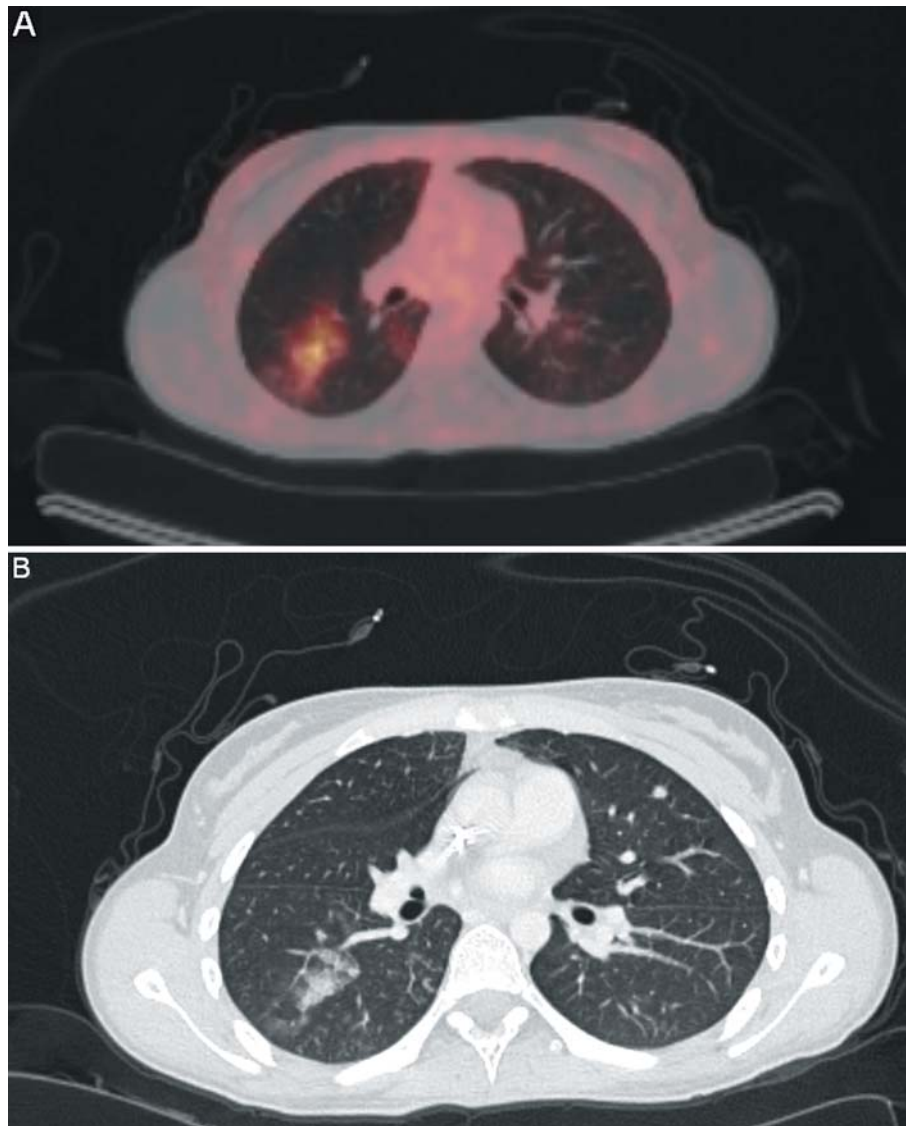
Fused fluorine- 18 fluorodeoxyglucose positron-emission tomography combined with computed tomography image with pathological uptake (A) and computed tomographic scan image (B) suggesting an infectious process in the right lung of a patient.
